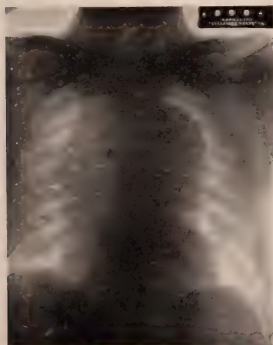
Large fusiform aneurysm. Marked expansile pulsation noted roentgenoscopically.
